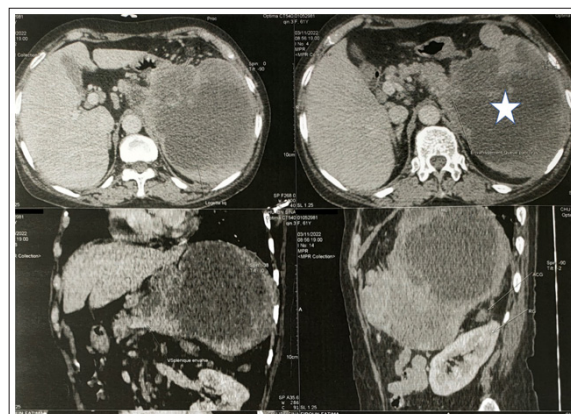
Abdominal computed tomography (CT) scan showed a 18 x 14 x 12 cm tissular heterogeneous mass, with irregular borders, located in the splenic hilum with extensive necrosis (white star)
